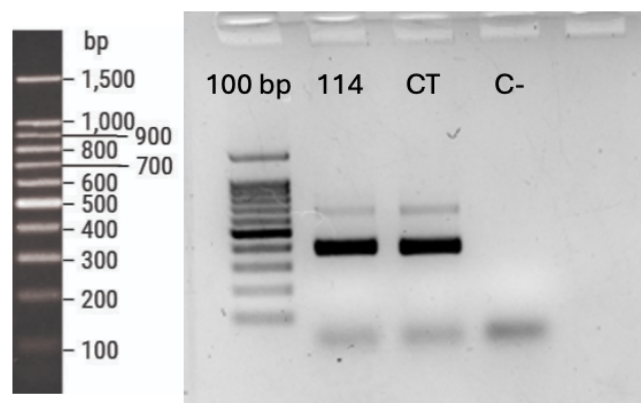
Conventional flanking PCR analysis of *PLXNA4*: Agarose gel electrophoresis of PCR products obtained from patient #114, a control sample and a negative control. Both patient and control sample showed amplification products of approximately 380 bp and 400 bp, the third band is an aspecific product; CT, control sample; C-, negative control; 100bp, 100 bp DNA ladder (Promega).
